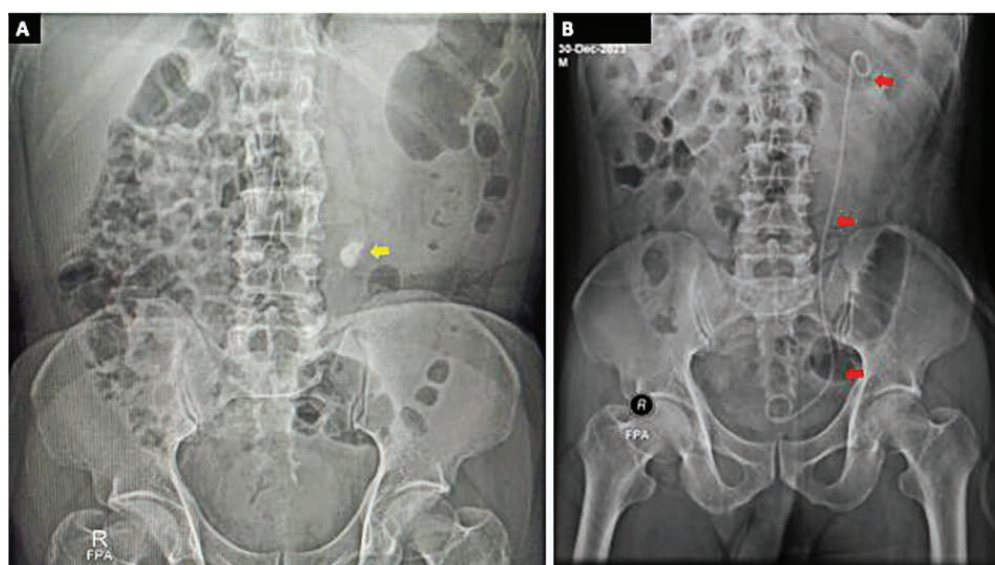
A kidney, ureter, and bladder (KUB) X-ray. (A) Postoperative proximal ureteral stone (yellow arrow). (B) Correct placement of the DJ stent in the ureter following laparoscopic ureterolithotomy (red arrow). All patients who underwent this technique had the correct placement confirmed by KUB X-ray.
